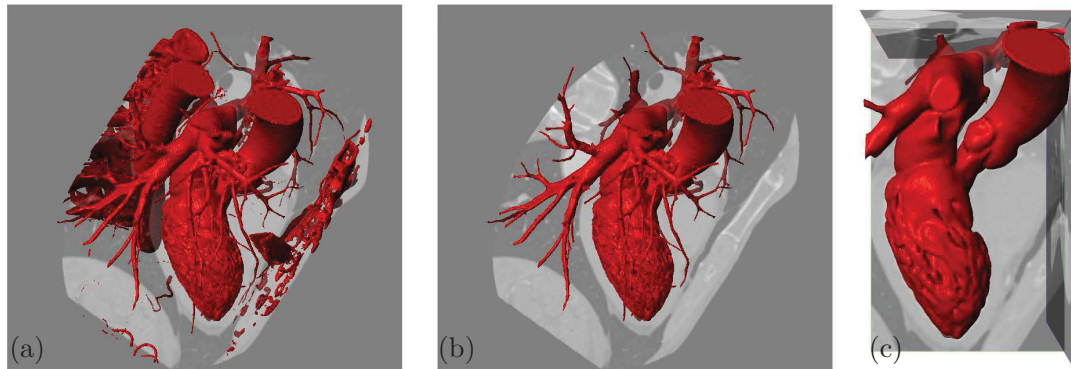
Segmentation from a CT scan. Slice of the volumetric image is depicted in transparency. Image (a) represents a segmentation only based on the *grey values* of the 3D image. Image (b) represents the same 3D model after manual treatments and image (c) the chosen area of interest for the blood computation.
